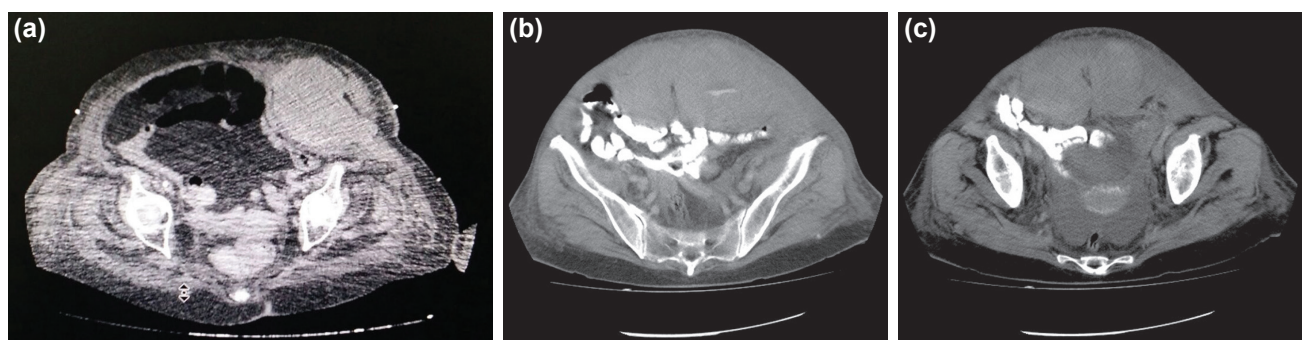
(a) Computed tomography scan showing Type I rectus sheath hematoma. (b) Type II hematoma. Computed tomography scan showing hyperdense bilateral hematoma. (c) Computed tomography scan showing Type III hematoma.
